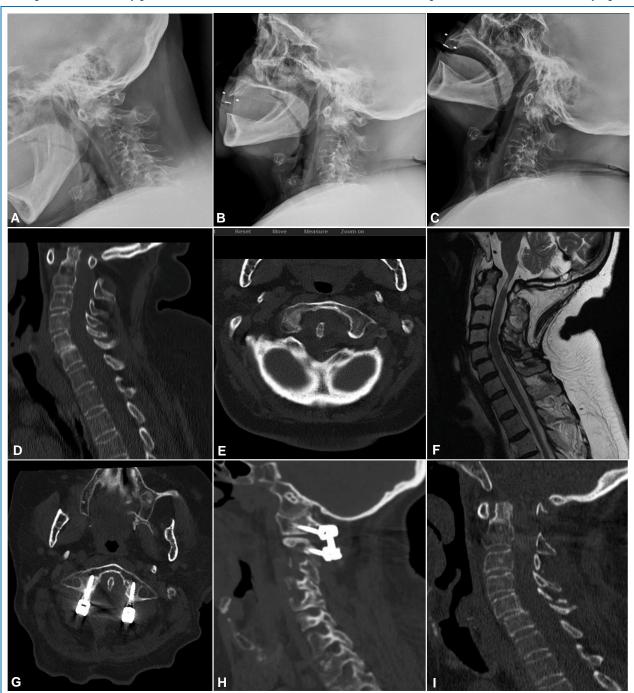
(Case 6): 56-year-old female patient with a 12-year history of rheumatoid arthritis, cesarean section, cholecystectomy, hysterectomy, bilateral hip replacement, on treatment with prednisone, methotrexate, azathioprine, leflunomide, and sulfasalazine. She presented posterior cervicalgia and quadriparesis. Laboratory tests showed elevated CRP and ESR. (A, B, C) The cervical functional radiograph showed the presence of atlantoaxial dislocation. (D, E, F) Cervical tomography and magnetic resonance imaging showed C1-C2 subluxation and a moderate narrow canal. (G, H, I) Surgery was performed by C1-C2 posterior cervical arthrodesis, achieving reduction of C1-C2. The clinical evolution was good, going from grade III on the Ranawat scale to grade II.
